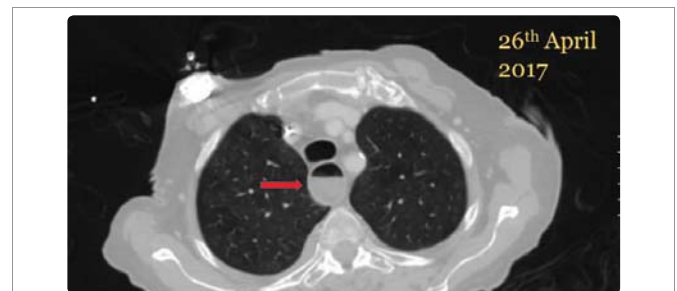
CT scan of the chest showing markedly dilated esophagus with a clear air fluid level (arrow).
